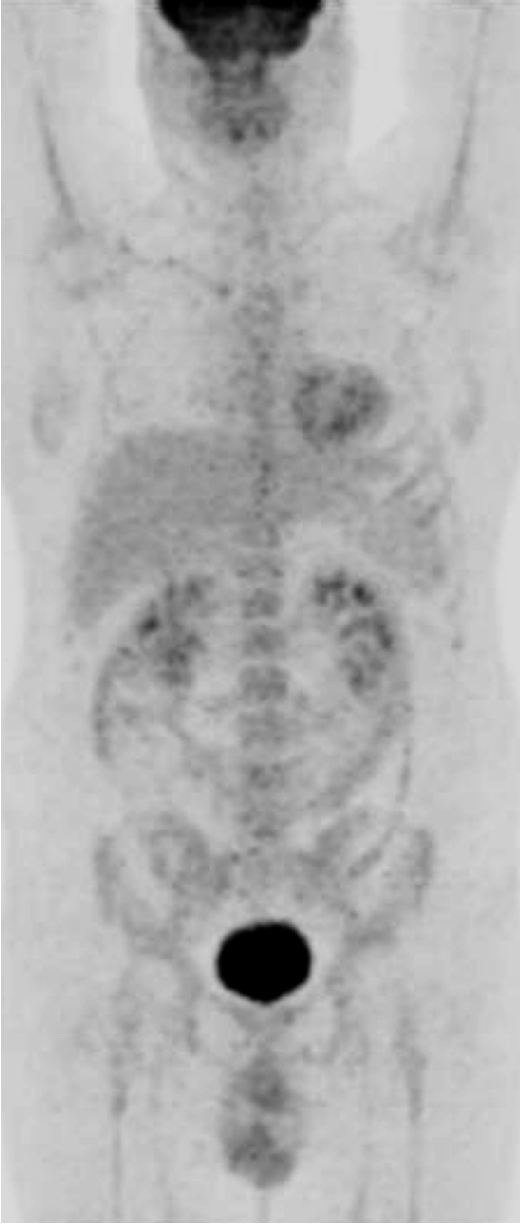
PET/CT was normal 3 months after ASCT
